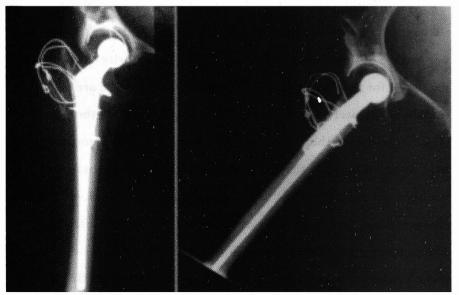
AP and lateral X-rays of the left hip after total hip arthroplasty with CDH components. The distal portion of the plate was intracortical allowing for stem placement without total plate removal.
